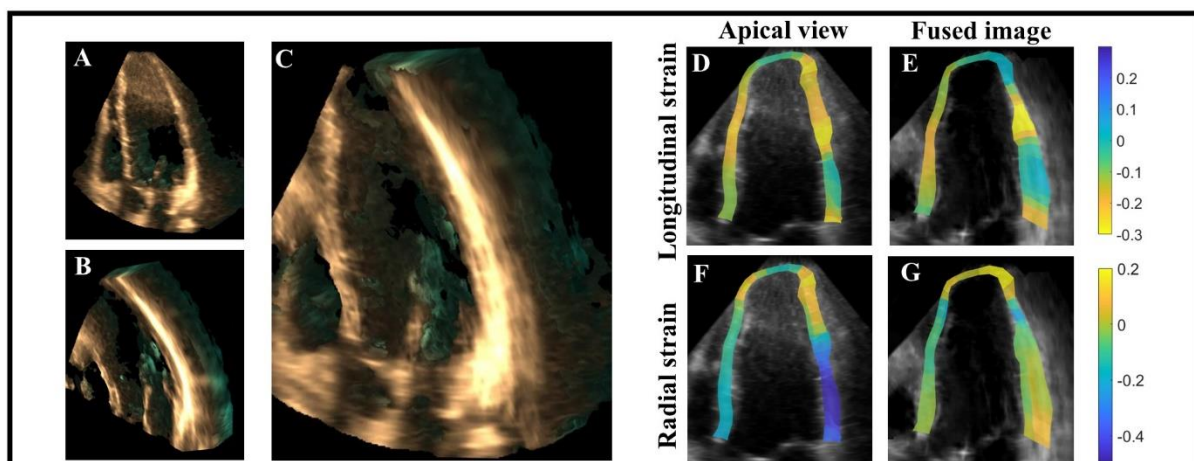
3D *in vivo* fusion results, created by fusing 3D volumes obtained from different views. A. Apical 3D volume, B. parasternal volume, and C. the resulting fused volume, showing enhanced field-of-view and image contrast, without image border artefacts. D-G display preliminary fusion strain results at end-systole. D. The longitudinal strain of the apical, and E. the fused image. F. The radial strain of the apical, and G. the fused image. Fusion strain improved speckle-tracking in general due to improved lateral resolution, and provided more accurate radial strain compared to a single view.
